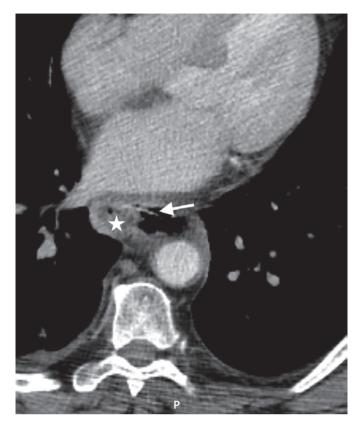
Axial view of chest CT scan revealing in the thoracic esophagus, in the same plane as the left atrium, a linear and dense object 30 mm in size (arrow), with signs of esophageal perforation and presence of an adjacent collection $(23 \times 31 \times 61 \text{ mm})$ (star).
